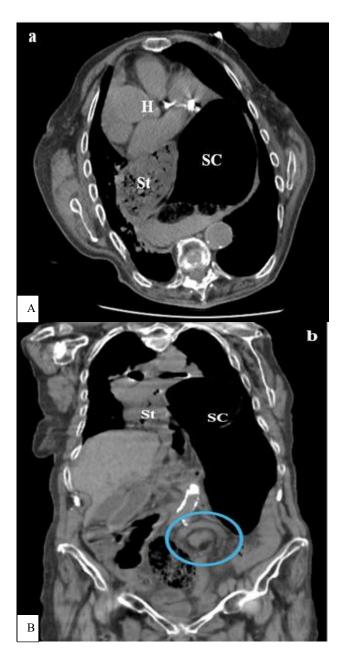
(A and B): CT scan of the chest and abdomen demonstrating a massive type IV hiatal hernia containing, (A) the entire stomach (St) and the apex of the sigmoid colon (SC) incarcerated within the posterior mediastinum, compressing and displacing the heart (H) to the right hemithorax; (B) and the classic "swirl" sign of twisted sigmoid mesenteric vessels (blue circle) confirming the presence of a sigmoid volvulus.
